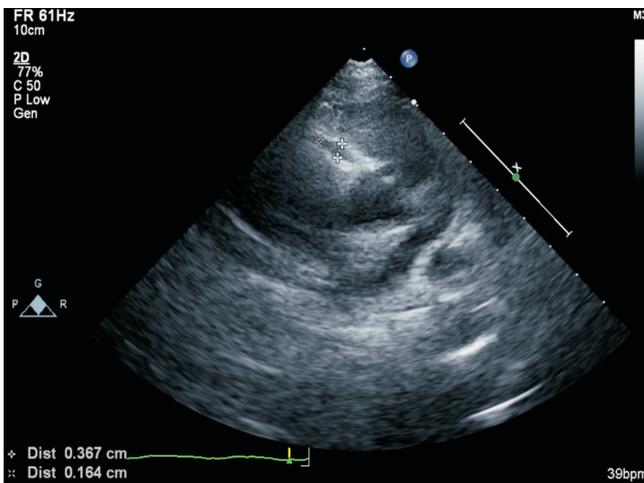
Right coronary artery dilatation by echocardiography in Kawasaki disease patient.
